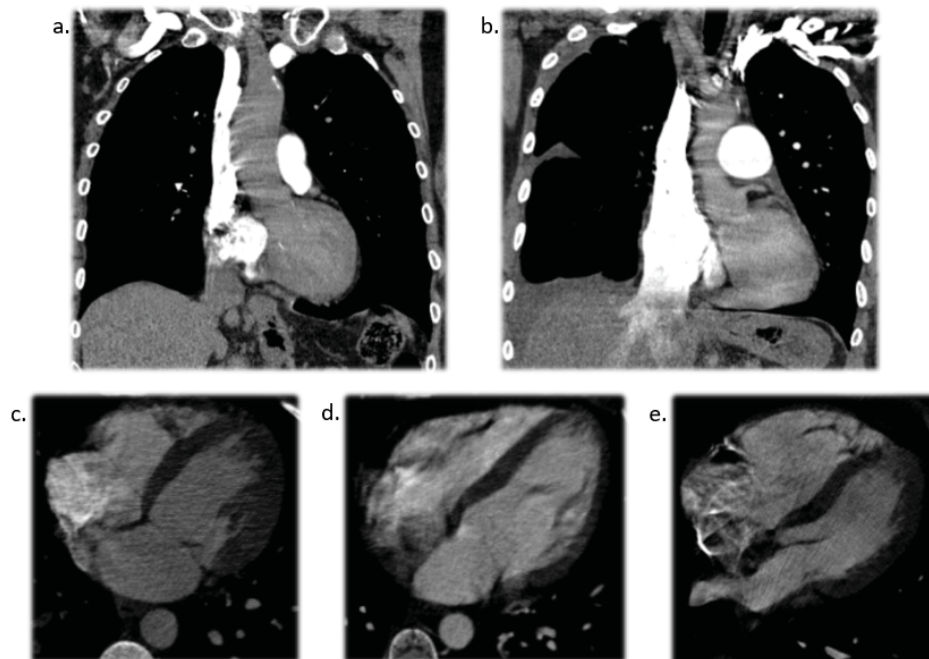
CTA features related to right heart strain and pulmonary artery hypertension. In (a) an example without IVC reflux. In (b) with IV reflux. In (c) showing normal position of interventricular septum. In (d) showing flattened interventricular septum. In (e) showing paradoxical interventricular septal bowing
